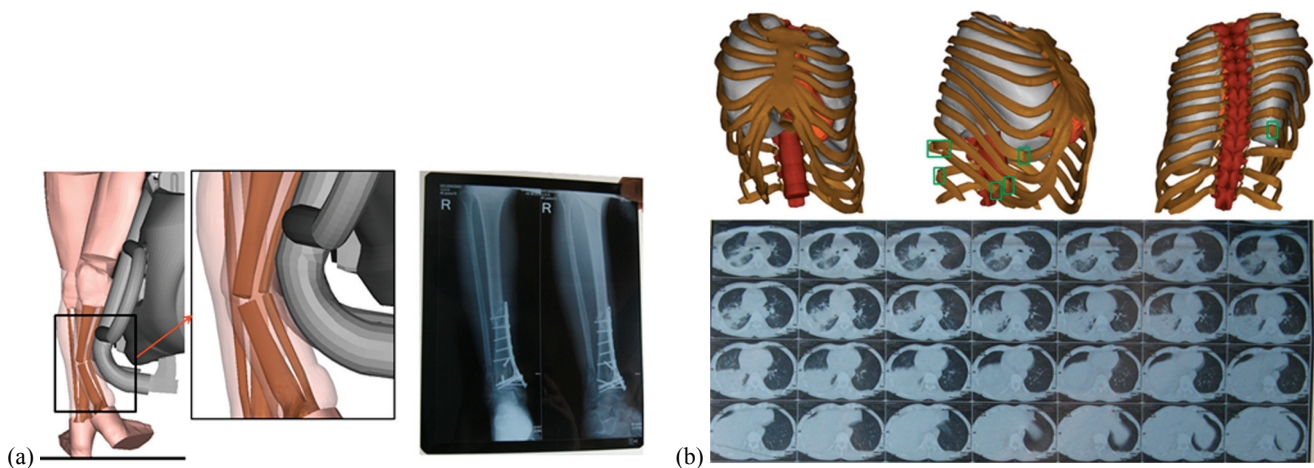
Predicted long bone fractures (a) and thorax deflection and rib fractures (b) together with X-ray and CT data from the hospital
